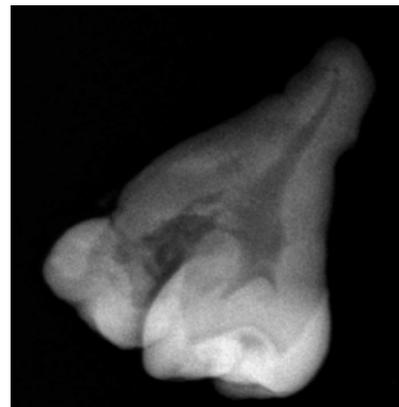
Case 7 (tab. 1). Radiograph of removed geminated tooth .
